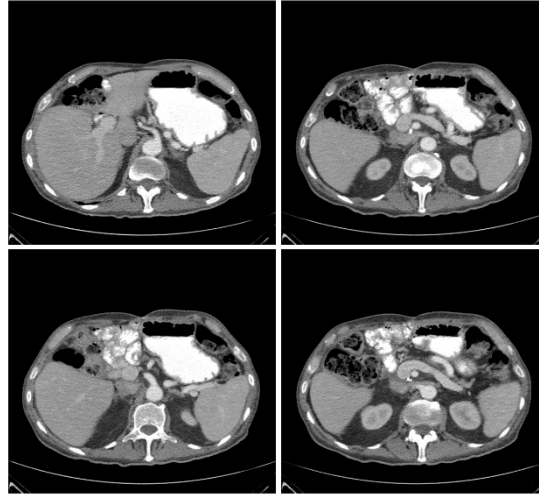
CT showing a subphrenic as well as subhepatic collection
